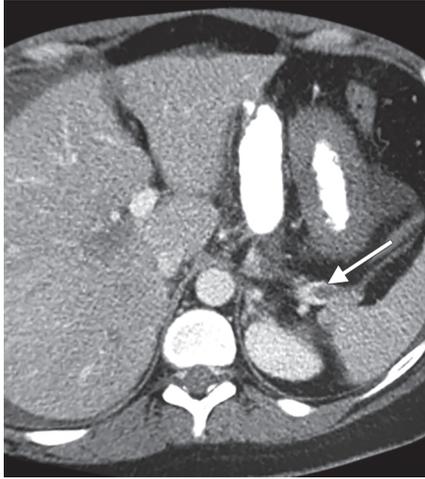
Abdominal CT scan with contrast showing superior mesenteric vein thrombosis (white arrow)
